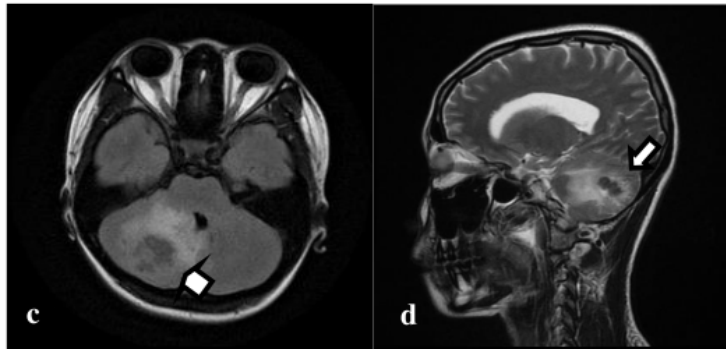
MRI findings: isointense on T1W1 (a), slightly hyperintense on T2W1 (b), appeared hypointense on T2 Fluid-Attenuated Inversion Recovery (FLAIR) (c), sagittal T2 (d)
